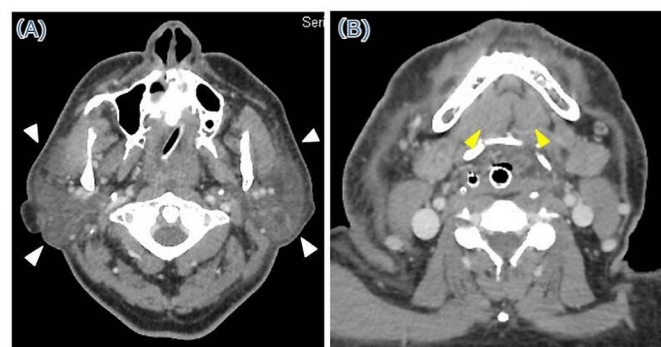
Contrast-enhanced CT shows swelling of the bilateral parotid (white arrow heads) (A) and sublingual glands (yellow arrow heads) (B) with surrounding fat stranding.
